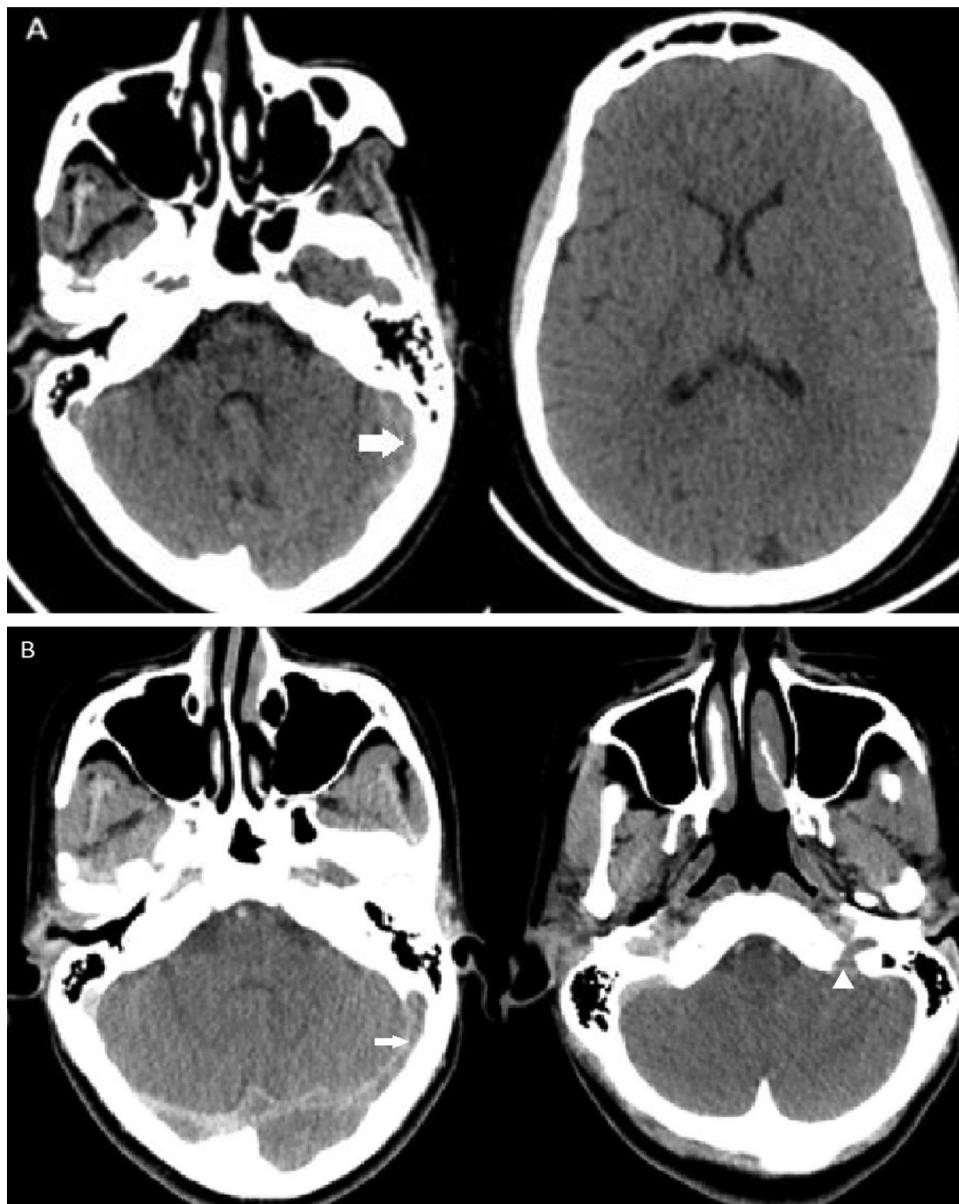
(A) Non-enhanced CT scan demonstrating spontaneous hyperdensity regarding left transverse sinus (white arrow). (B) Enhanced CT scan showing thrombosis of the left transverse and sigmoid sinus (white arrow) extended to the jugular vein (arrowhead).
